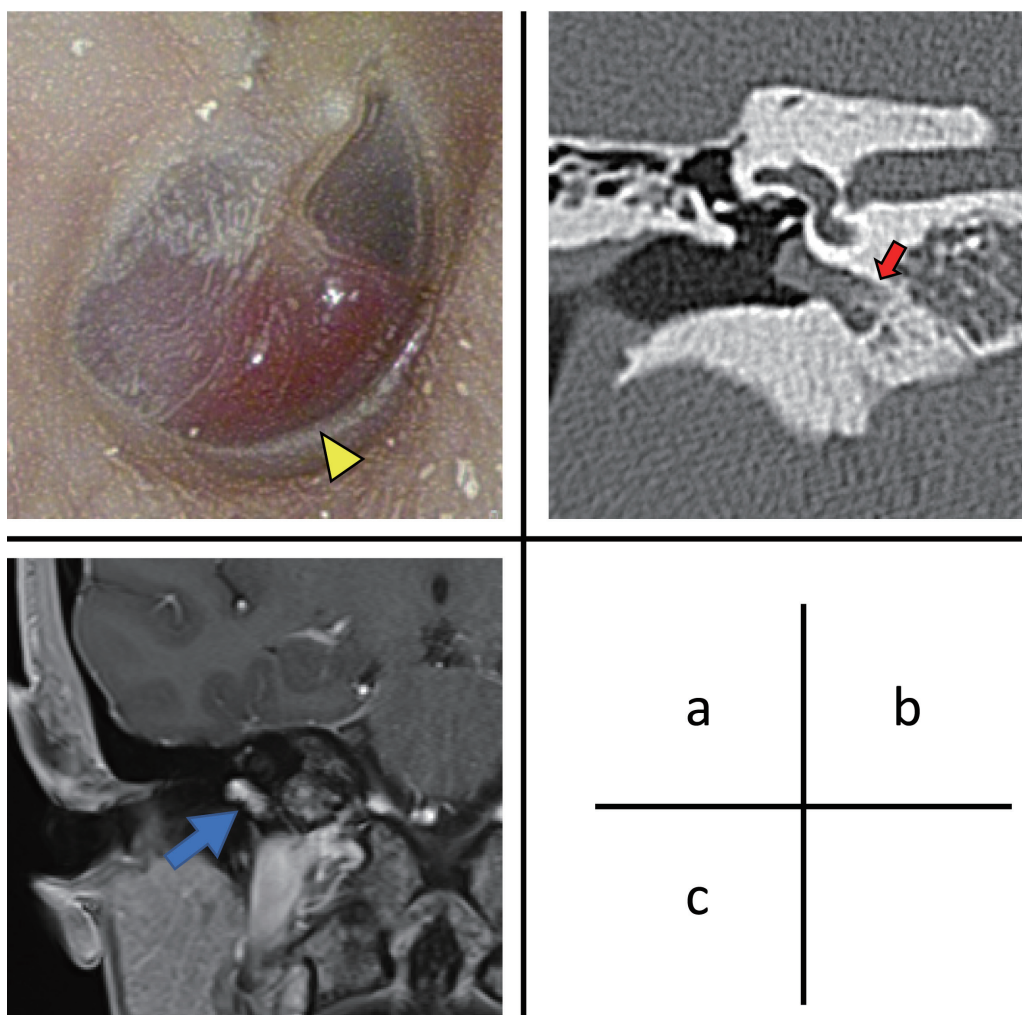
Findings on physical examination and imaging. a) A red pulsatile mass in the lower half of the right tympanic cavity (yellow arrowhead). b) Computed tomography image of the temporal bone shows an isodense area with slight bone invasion (red arrow) mainly in the right hypotympanum. c) Contrast-enhanced magnetic resonance imaging of the head reveals a mass with relatively strong contrast effect in the tympanic cavity (blue arrow).
